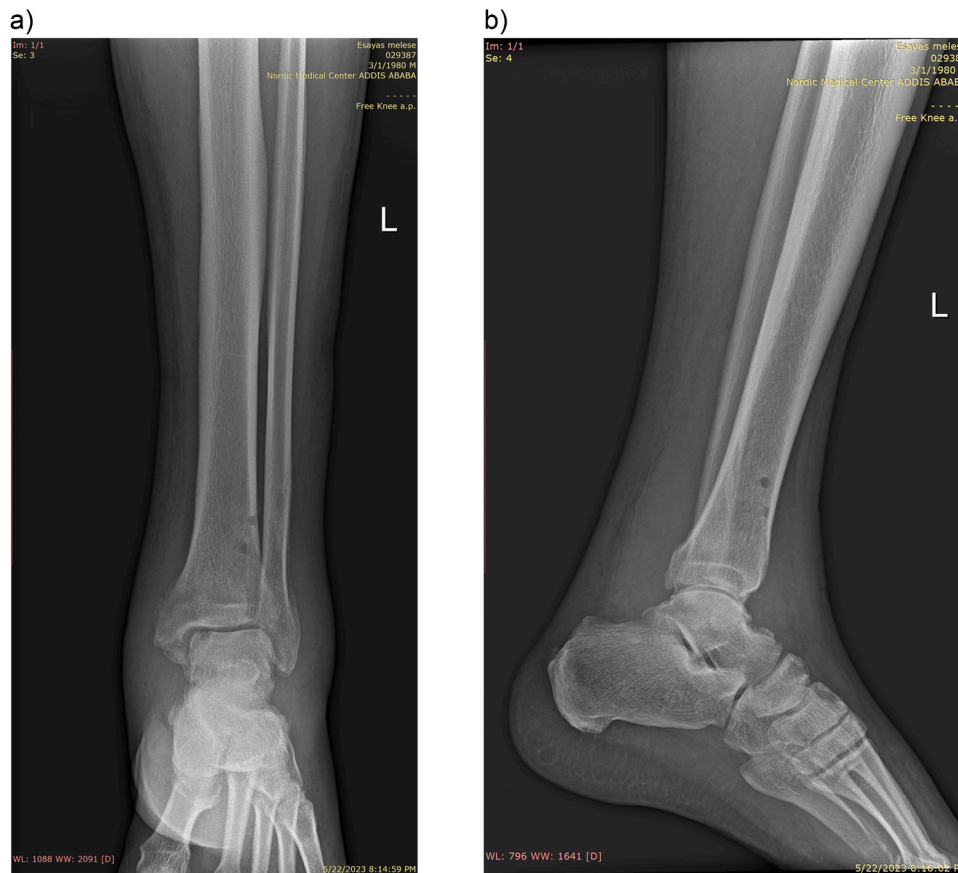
Ankle X-ray obtained during follow-up, approximately one month after drainage of the ankle abscess. X-ray shows no signs of bone abscess or sequestrum. Signs of prior bone drilling and arthritis are present, without significant joint space narrowing. a) AP view. b) Lateral view.
